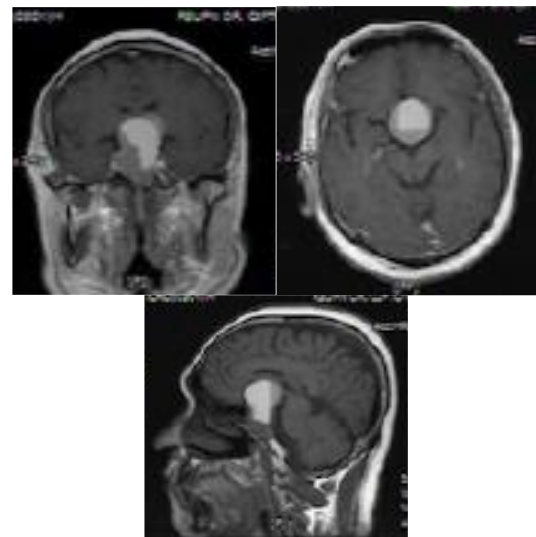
MRI contrast showed tumor in sellar region with hemorrhage
